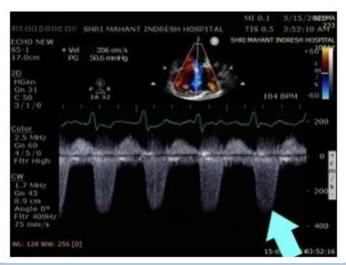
(d) - Continuous Wave Doppler at tricuspid valve showing markedly elevated right ventricular systolic pressures.
